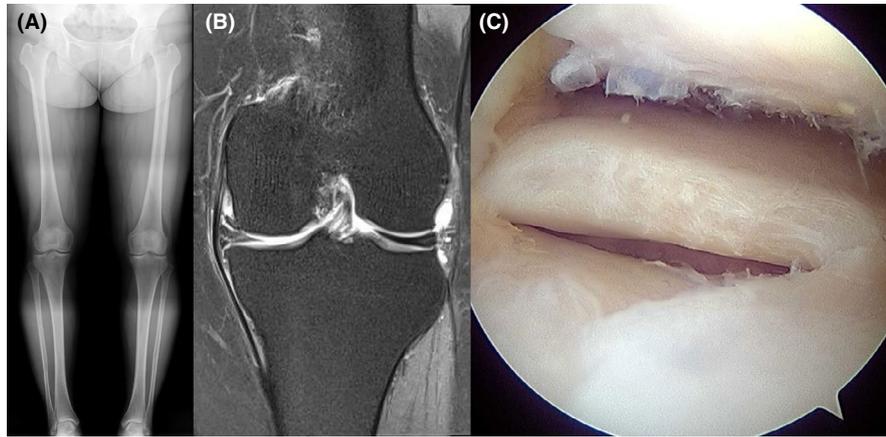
Before high tibial osteotomy (A). A preoperative standing anteroposterior radiograph of the bilateral lower extremities shows a left hip-knee-ankle angle of 5.3° (B) Magnetic resonance imaging of the left knee joint reveals a medial meniscus tear with cartilage denudation of the medial femoral condyle and an incomplete type of lateral discoid meniscus. (C) Arthroscopic saucerization was performed to address the lateral discoid meniscus
